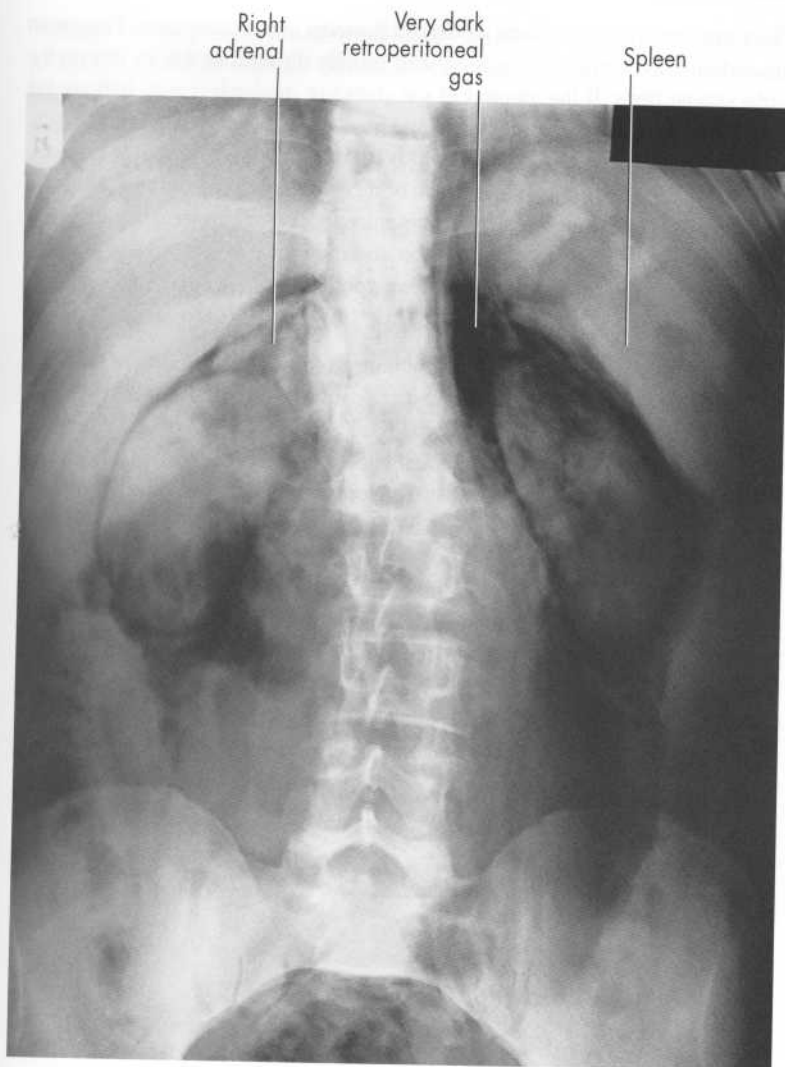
Retroperitoneal gas – old X-ray from a deliberate case of 'presacral pneumography'. Note the intense 'negative contrast' highlighting of the kidneys. Note also the enlarged spleen and big right adrenal gland.
